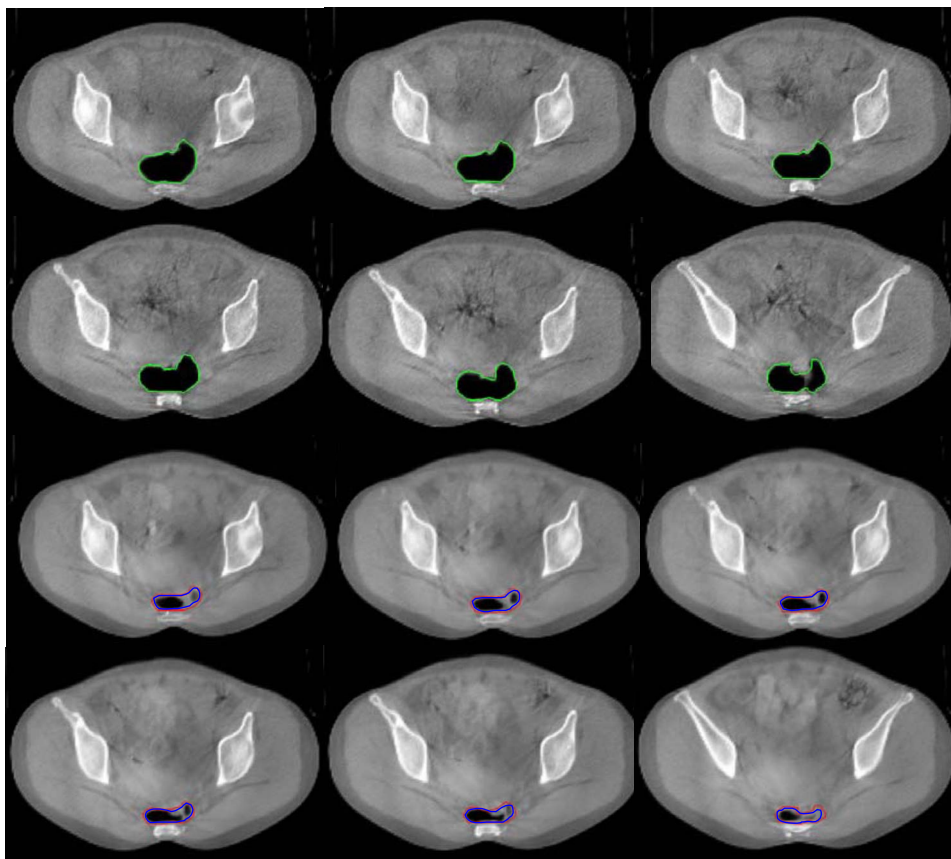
Rectal contour mapping for a rectal cancer case. The first and second rows show six axial slices in the pCT image. The third and fourth rows are the corresponding slices in the CBCT image.
